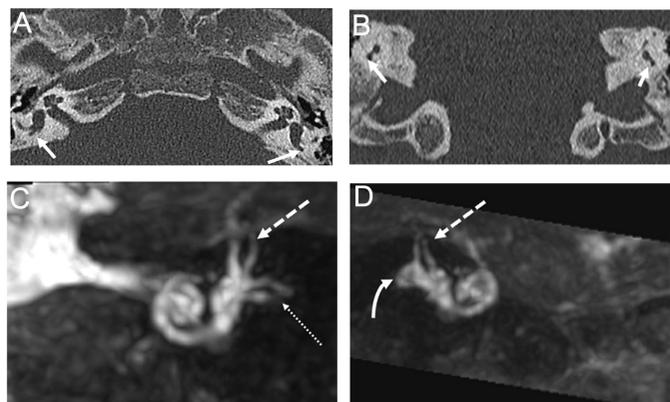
Axial (A) and coronal (B) computed tomography scan images of the petrous temporal bone demonstrate bilateral hypoplastic posterior semicircular canals (arrow). Selected maximum intensity projection reconstructions of the Magnetic Resonance Imaging (C and D) demonstrate a small and dysplastic left posterior semicircular canal (curved arrow). Similar appearances were noted on the right. Normal superior (dashed arrow) and lateral (dotted arrow) semicircular canals are shown.
